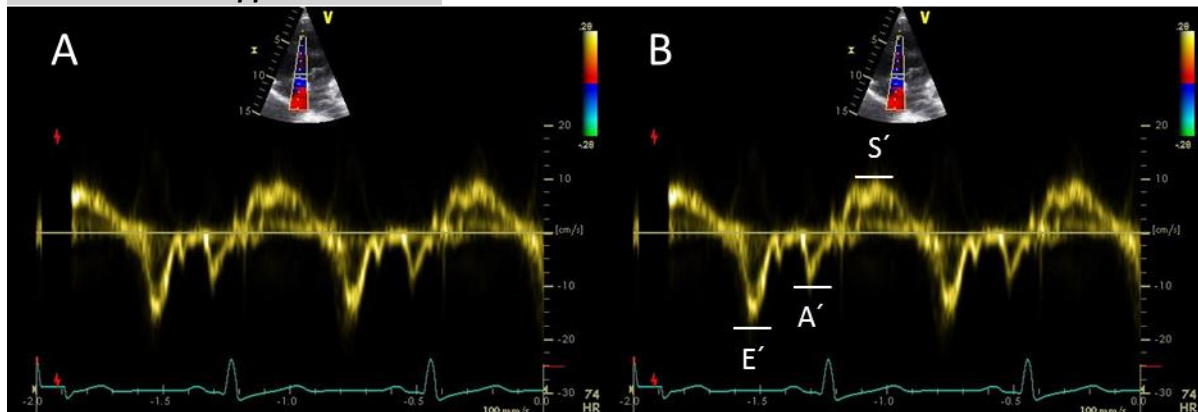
Tissue Doppler medial MV (A) and measurement of tissue Doppler medial MV (B)
